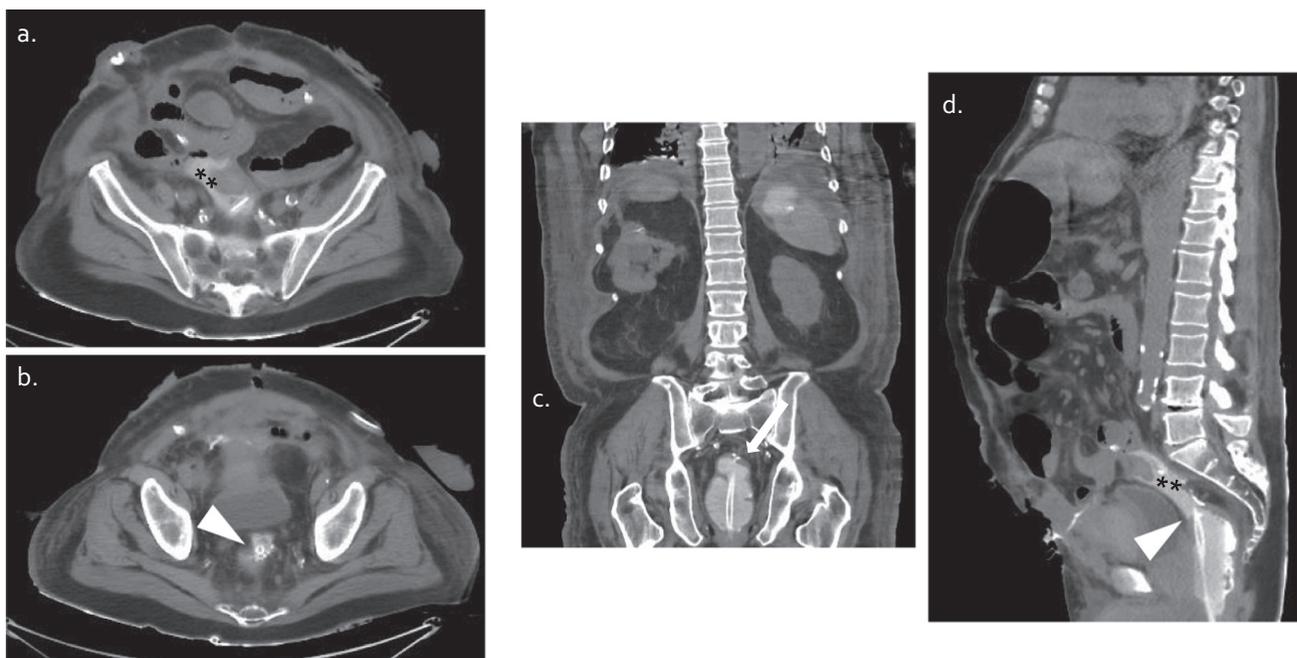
Stump leak: axial (a, b), coronal (c), and sagittal (d) CT images in a patient after undergoing Hartmann's procedure. Note the rectal stump (arrow). Rectal contrast administered via rectal tube is seen extravasating from the superior aspect of the stump (arrowhead) with a collection seen in the pelvis (stars).
